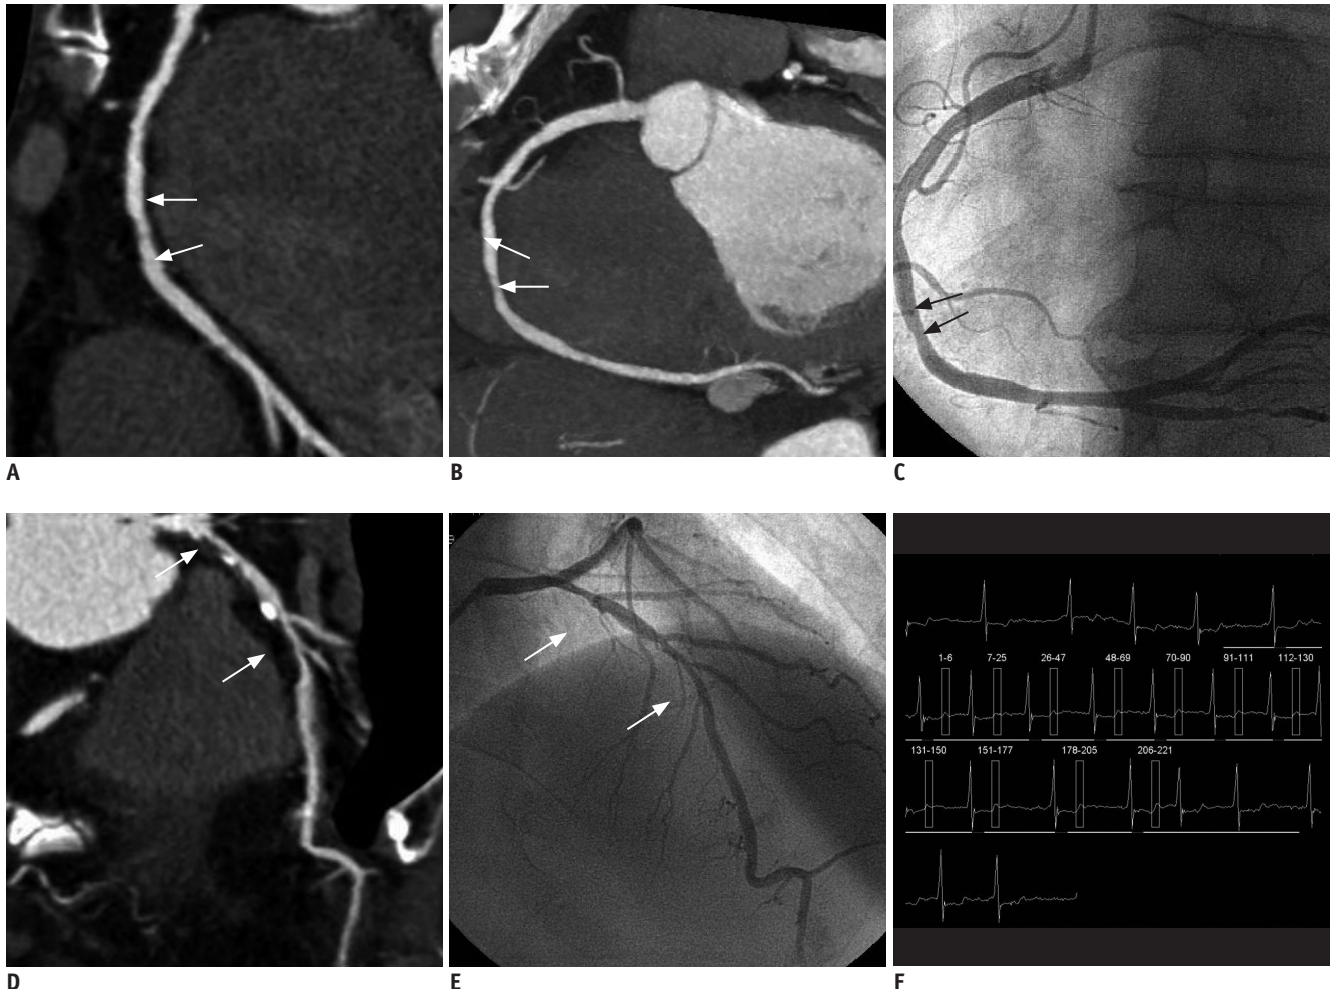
CT angiography of 86-year-old man with atrial fibrillation (mean heart rate: 93 bpm, range: 66-143 bpm).
